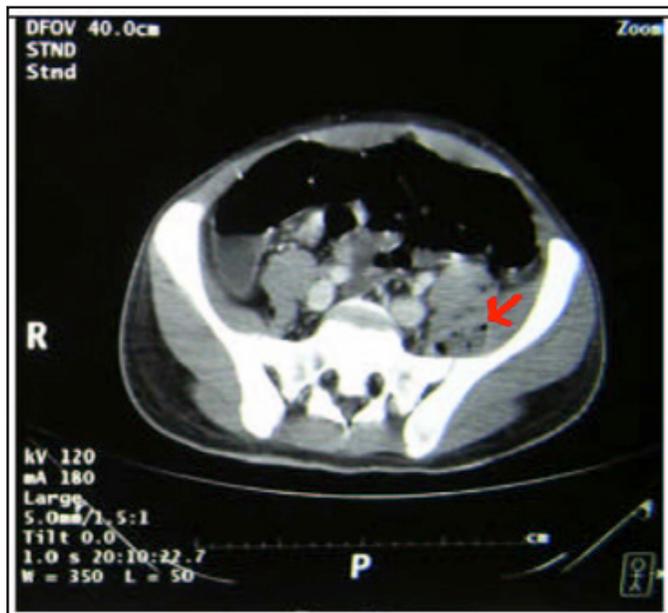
CT scan showing iliopsoas abscess – arrow
